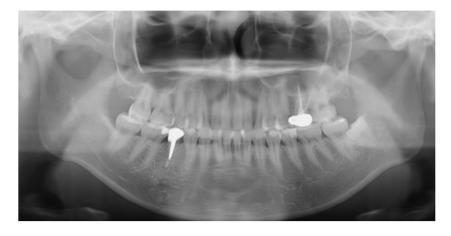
$Posttreatment\ lateral\ cephalogram\ and\ panoramic\ radiograph.$ $190x254mm\ (300\ x\ 300\ DPI)$
